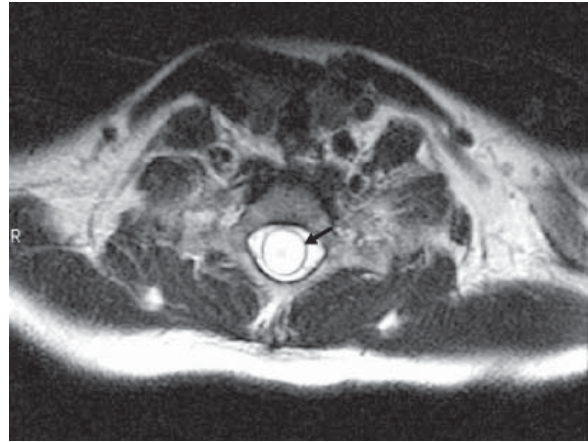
T2-weighted axial MRI of the large syrinx seen in Figure 1. The arrow is on the thin circular rim of the spinal cord with the interior of this structure representing the syrinx.
